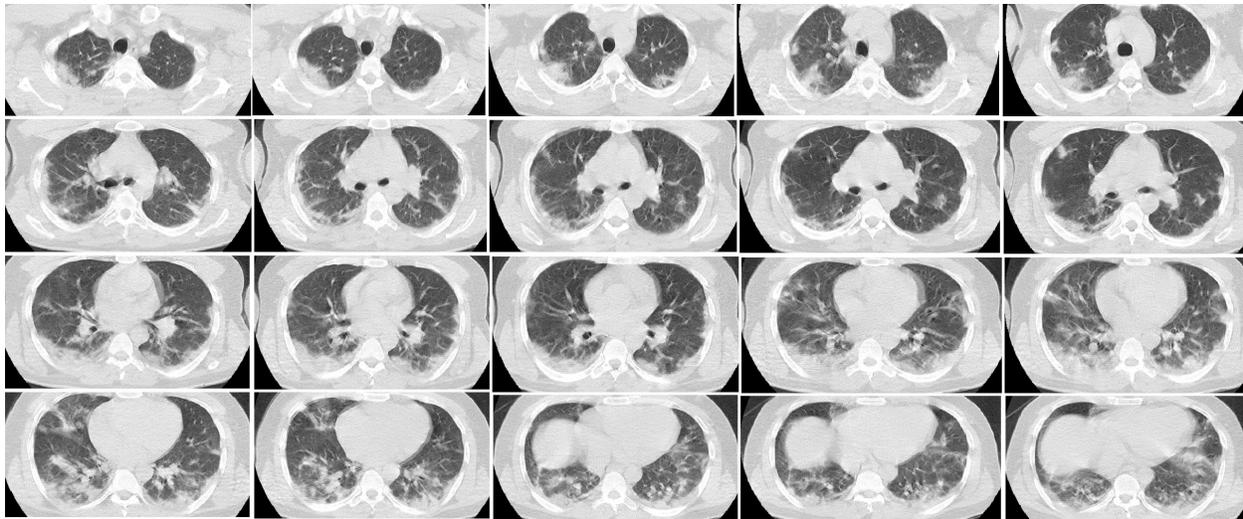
Chest CT scan of case 7 shows patchy predominantly peripheral ground glass opacities and consolidations in both lungs supporting the COVID-19 diagnosis
